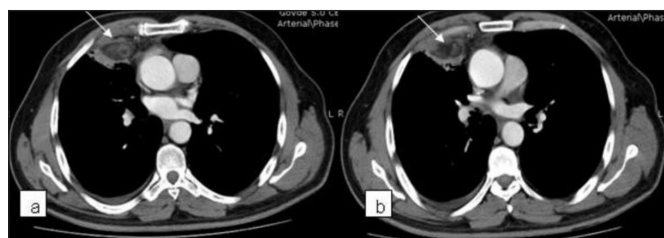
Axial contrast-enhanced chest CT shows an anterior mediastinal ovoid fat attenuation lesion (arrows) with intrinsic and surrounding soft tissue attenuation stranding.
